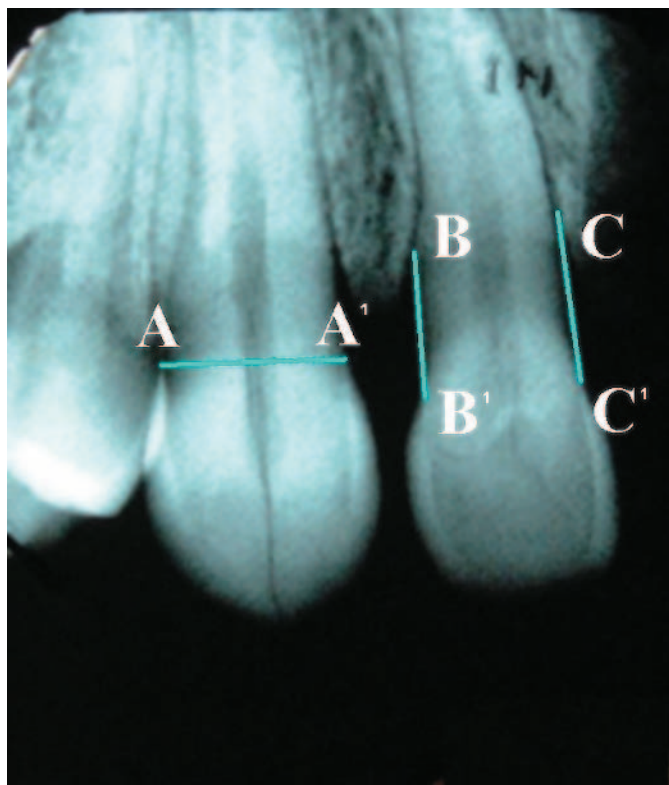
Intraoral x-ray taken with the imaging device. The horizontal (A-A') and both vertical measuring points (B-B', C-C') are shown.
